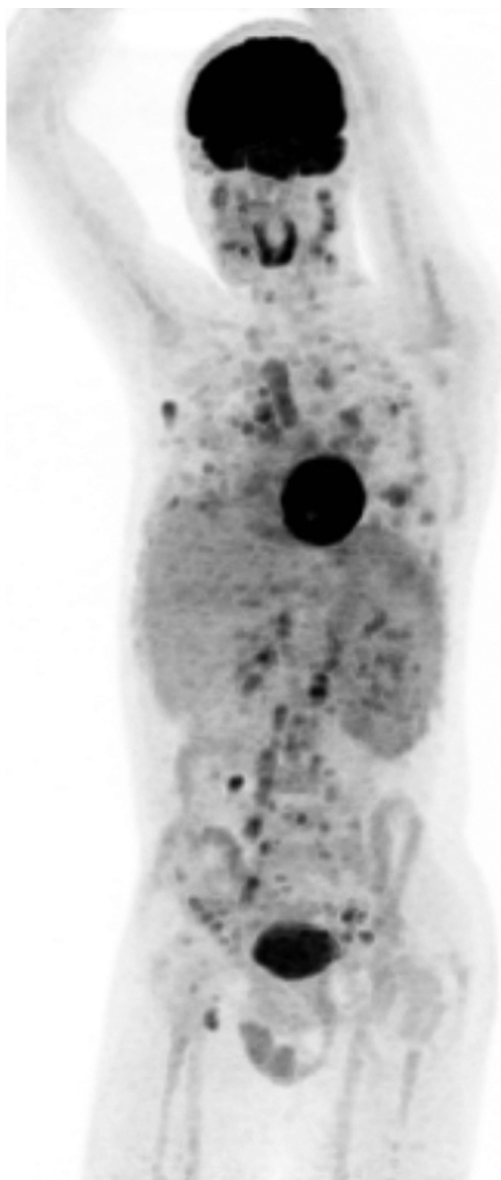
FDG-PET, maximum intensity projection. Diffuse supra- and infra-diaphragmatic distribution of FDG-avid adenopathies with increased captation of the spleen. Diffuse FDG-avid lesions spread in the lung parenchyma.
